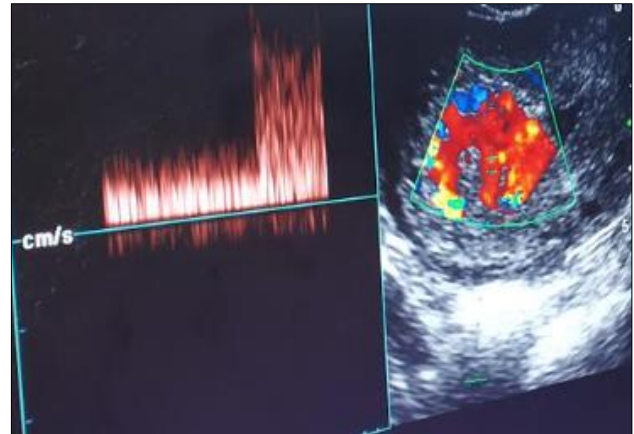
Transvaginal sonography and doppler image of hypervascular RPOC.
